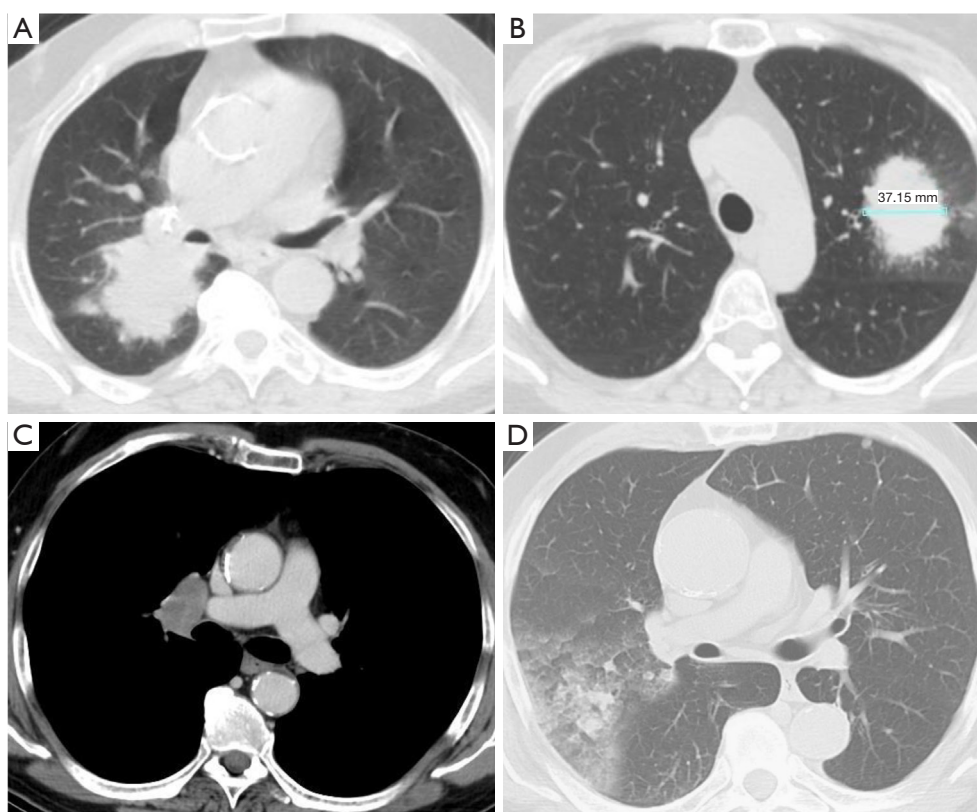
Current indication for a systematic endosonographic mediastinal staging in cN0/N1 NSCLC patients. (A) Primary tumor “centrally-located”; (B) primary tumor >3 cm, (C) cN1 status; (D) primary tumor lacking PET uptake. NSCLC, non-small cell lung cancer; PET, positron emission tomography.
